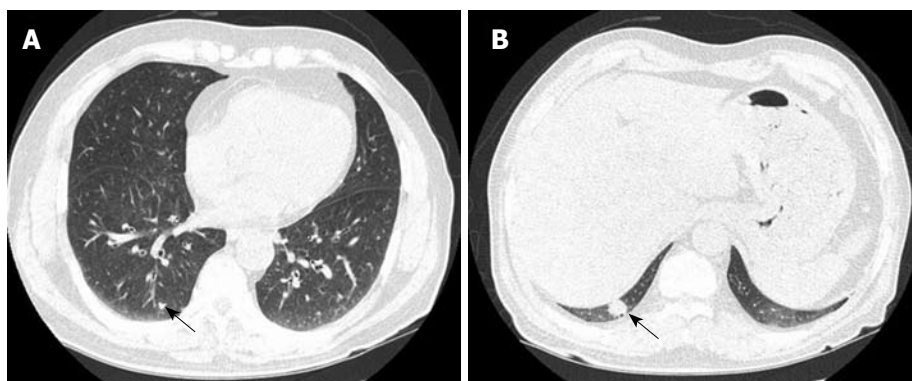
A chest CT scan showed very tiny nodules in both lungs (A) and approximately 15-mm-sized nodular lesions in the posterior basal segment of right lower lobe (B) (arrows).
